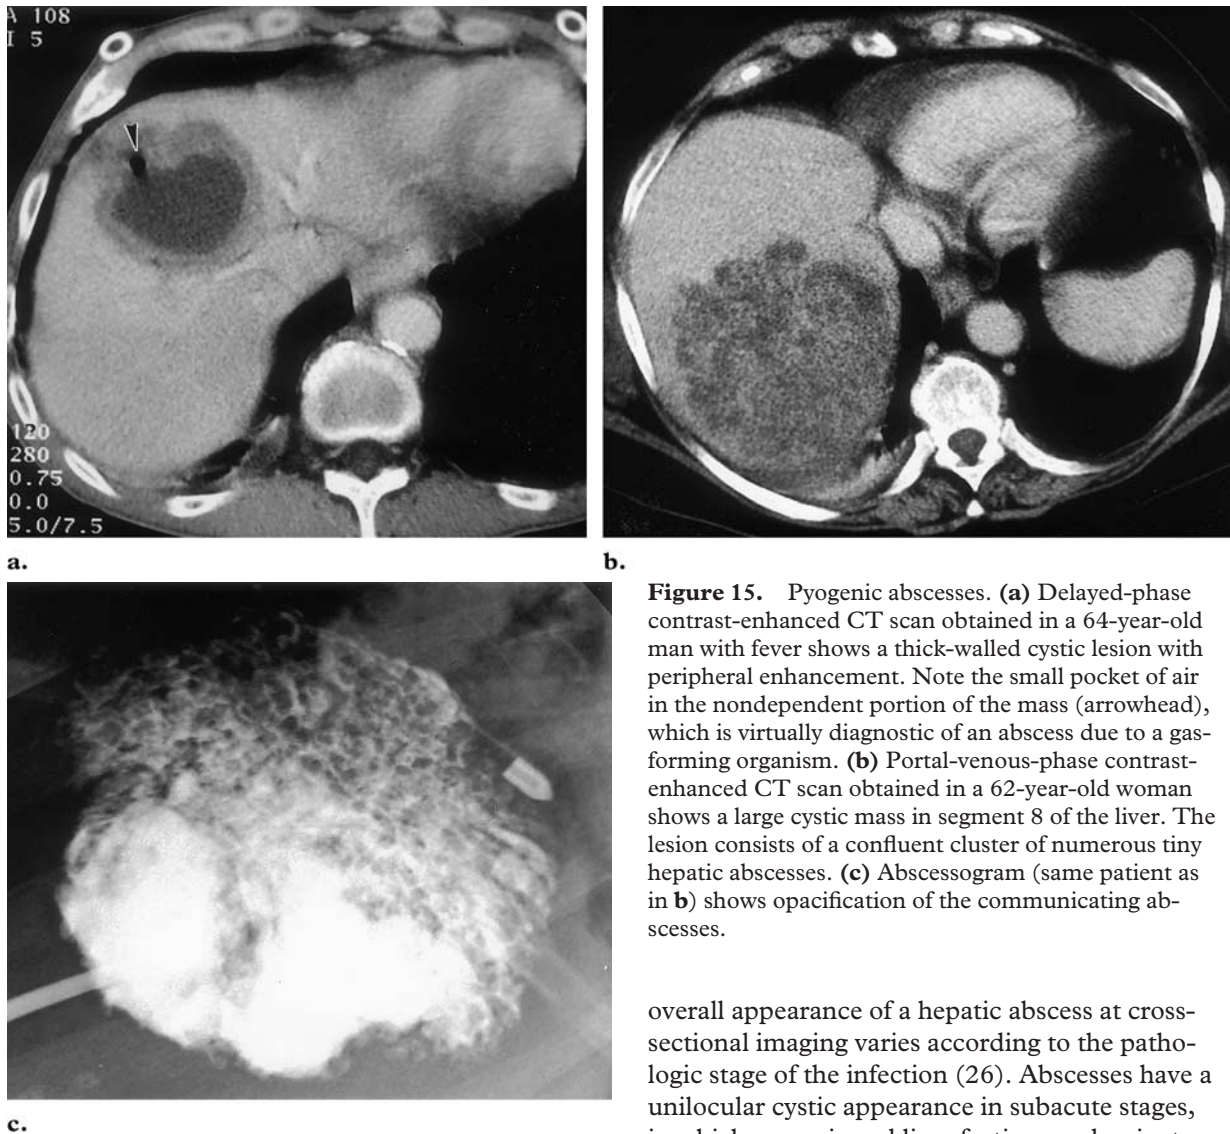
Pyogenic abscesses. (a) Delayed-phase contrast-enhanced CT scan obtained in a 64-year-old man with fever shows a thick-walled cystic lesion with peripheral enhancement. Note the small pocket of air in the nondependent portion of the mass (arrowhead), which is virtually diagnostic of an abscess due to a gas-forming organism. (b) Portal-venous-phase contrast-enhanced CT scan obtained in a 62-year-old woman shows a large cystic mass in segment 8 of the liver. The lesion consists of a confluent cluster of numerous tiny hepatic abscesses. (c) Abscessogram (same patient as in b) shows opacification of the communicating abscesses.
